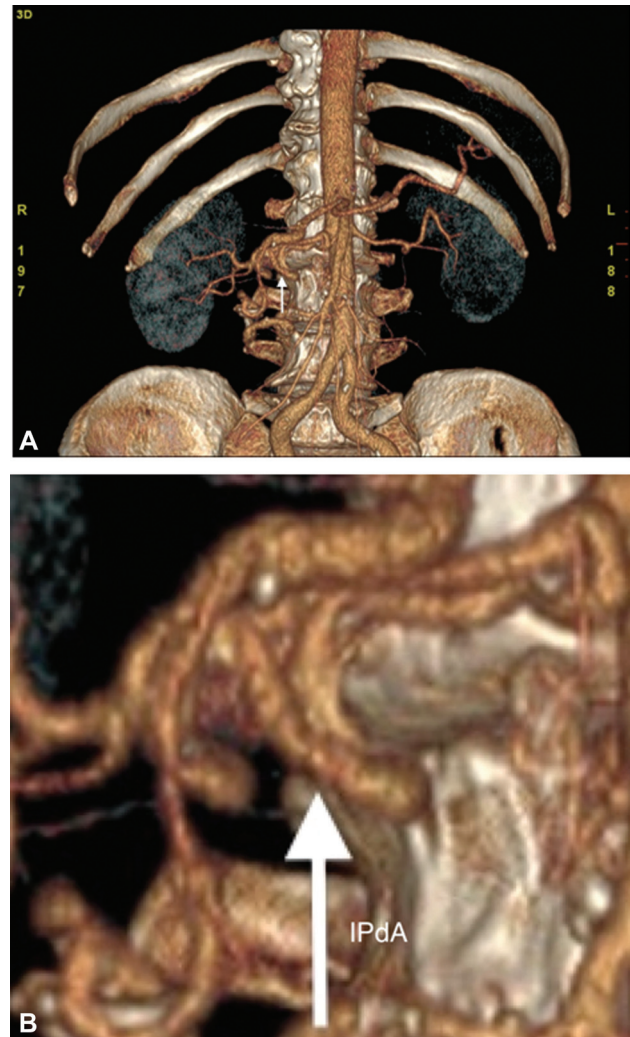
Three-dimensional volume-rendered standard (A) and zoomed-in (B) computed tomographic images displaying the tortuous and enlarged inferior pancreaticoduodenal artery (IPdA; arrow).
